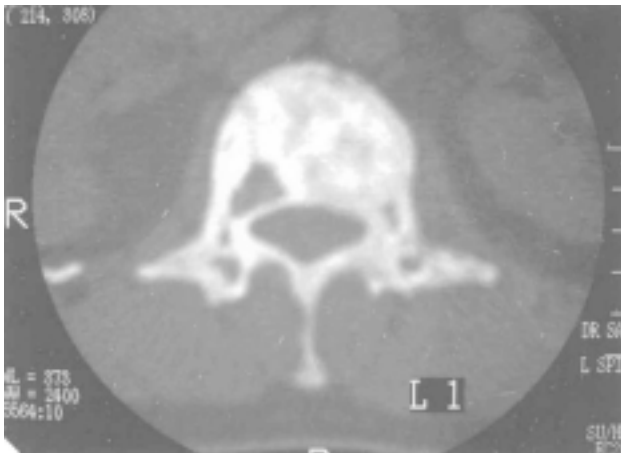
CT scan of first lumbar vertebra.
